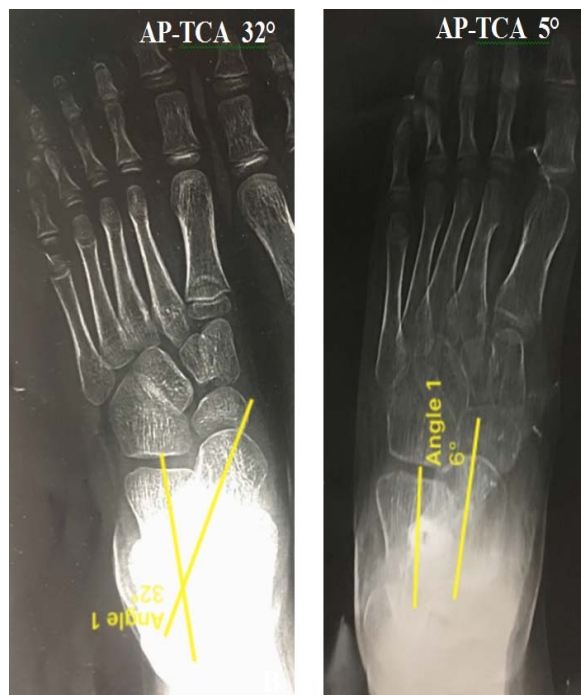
Radiographs showing measurement of preop. (A) and postop. (B) AP-TCA angles..
